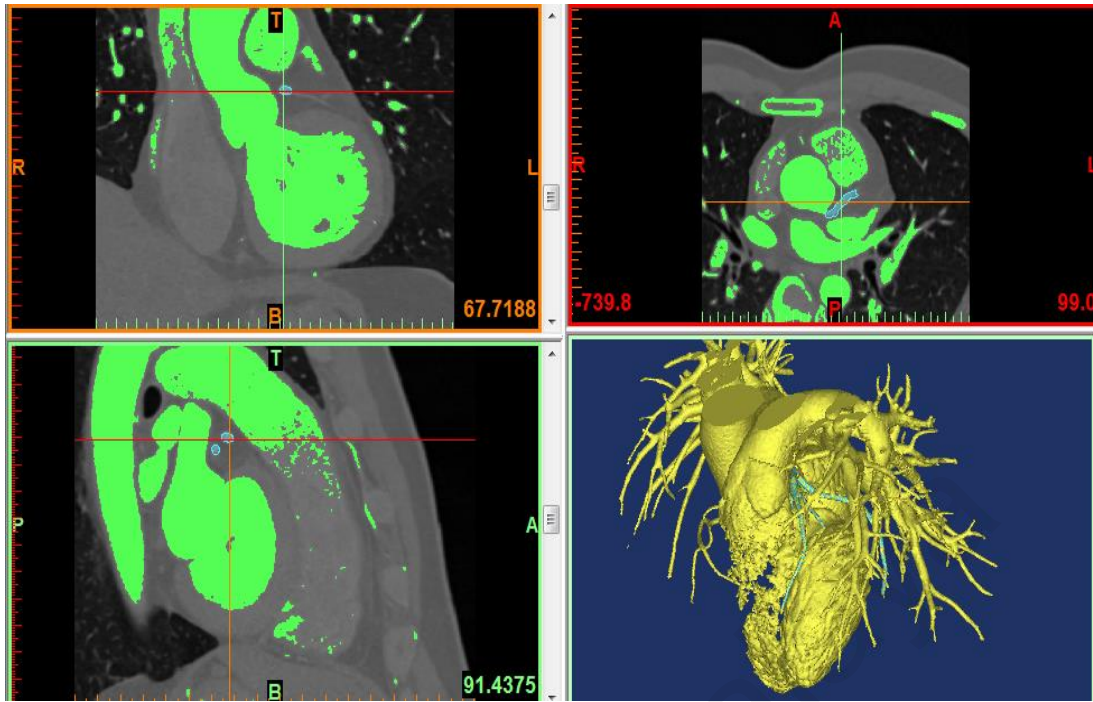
2D CT scan images with 3D volume rendering image of normal left coronary artery
